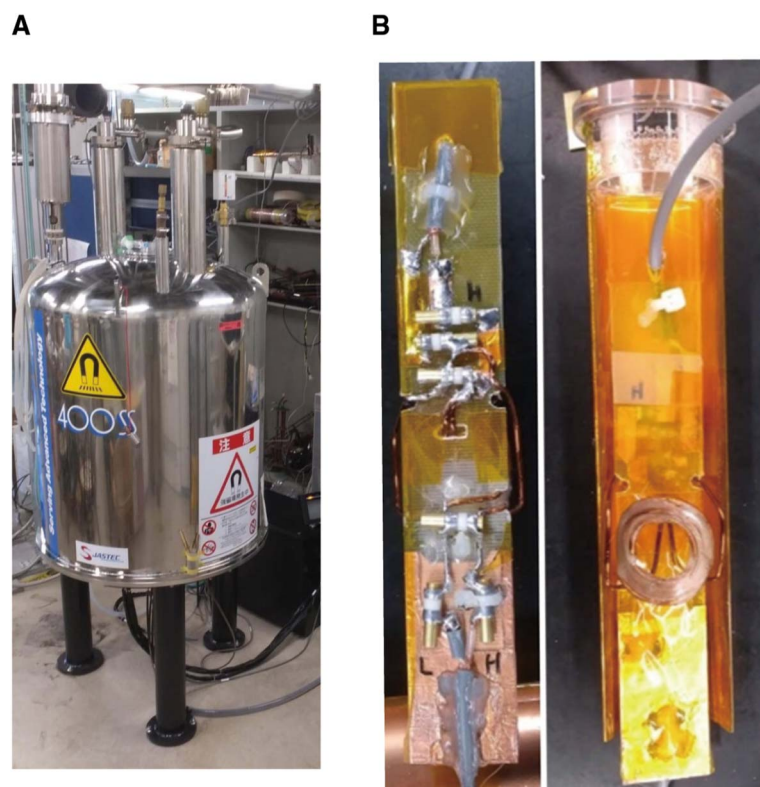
^{23}Na MRI and ^1H MRI equipment: (A) The 9.4-T vertical standard-bore superconducting magnet and (B) the ^1H and ^{23}Na surface coil.
